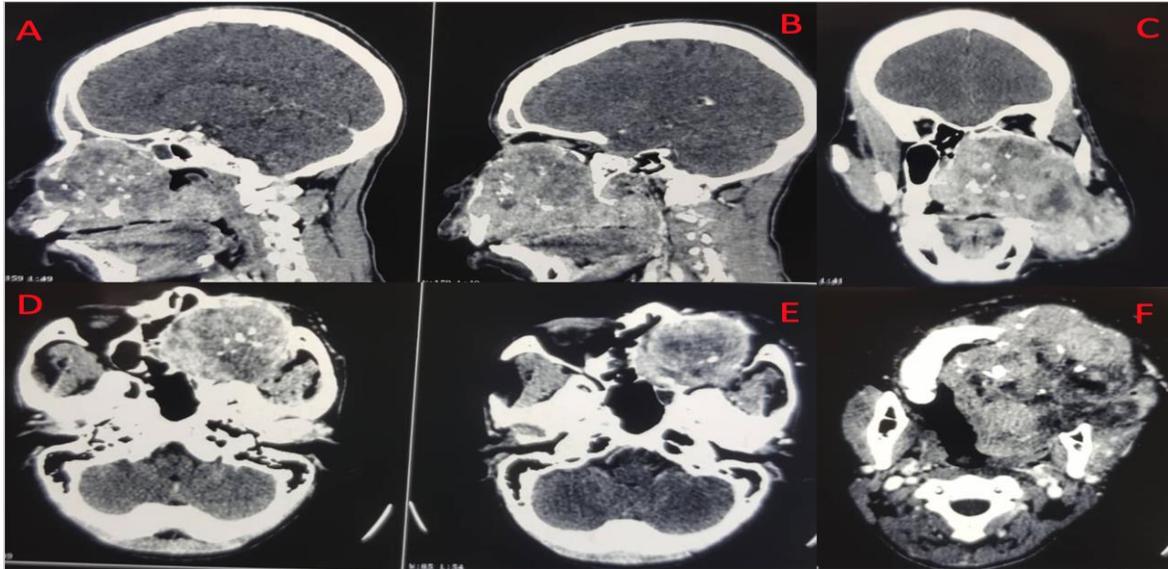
Craniofacial CT Scan (soft tissue window) with views: A, B (sagittal), C (coronal), D, E and F (axial) show huge area of iso-dense mass interspersed with hyper-dense structures and extensive osteolytic destruction involving the maxilla, left maxillary antrum, nasal cavity crossing the midline, infratemporal, pterygomaxillary space and superiorly the left orbit, ethmoid and aborting the base of the skull.
